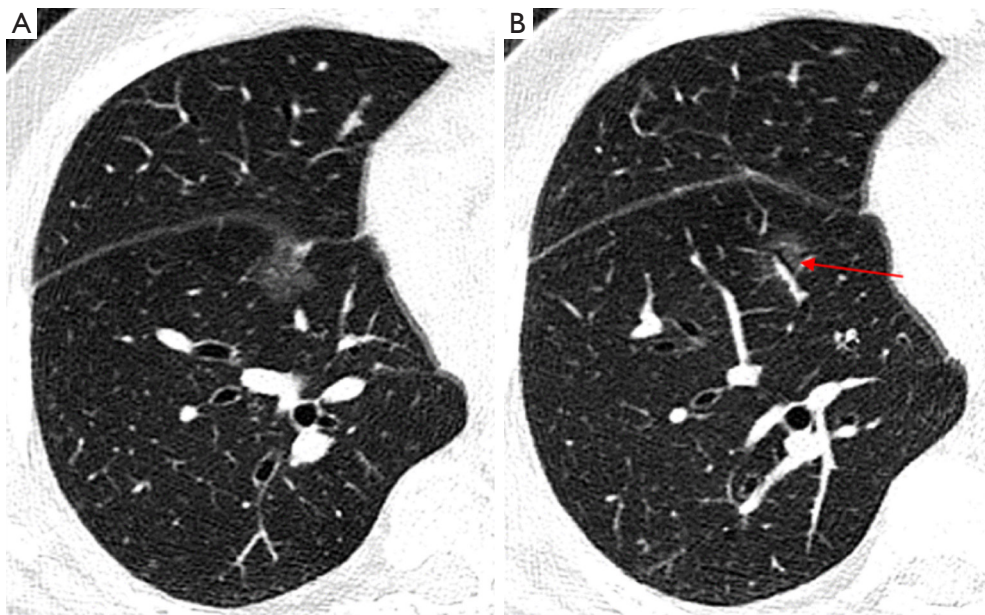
AIS. F, 65 y/o; pulmonary nodules for 2 months. (A,B) A pGGN in the anterior basal segment of the right inferior lung; interface: clear; size: about 17 mm × 18 mm; CT value: -665 ± 89.8 HU; lobulation sign; tumor vascular sign (type II); air bronchial sign (type I, as indicated by the arrow); pleural indentation sign (type d). AIS, adenocarcinoma in situ; F, female; y/o, years old; pGGN, pure ground-glass nodule; CT, computed tomography; HU, Hounsfield unit.
